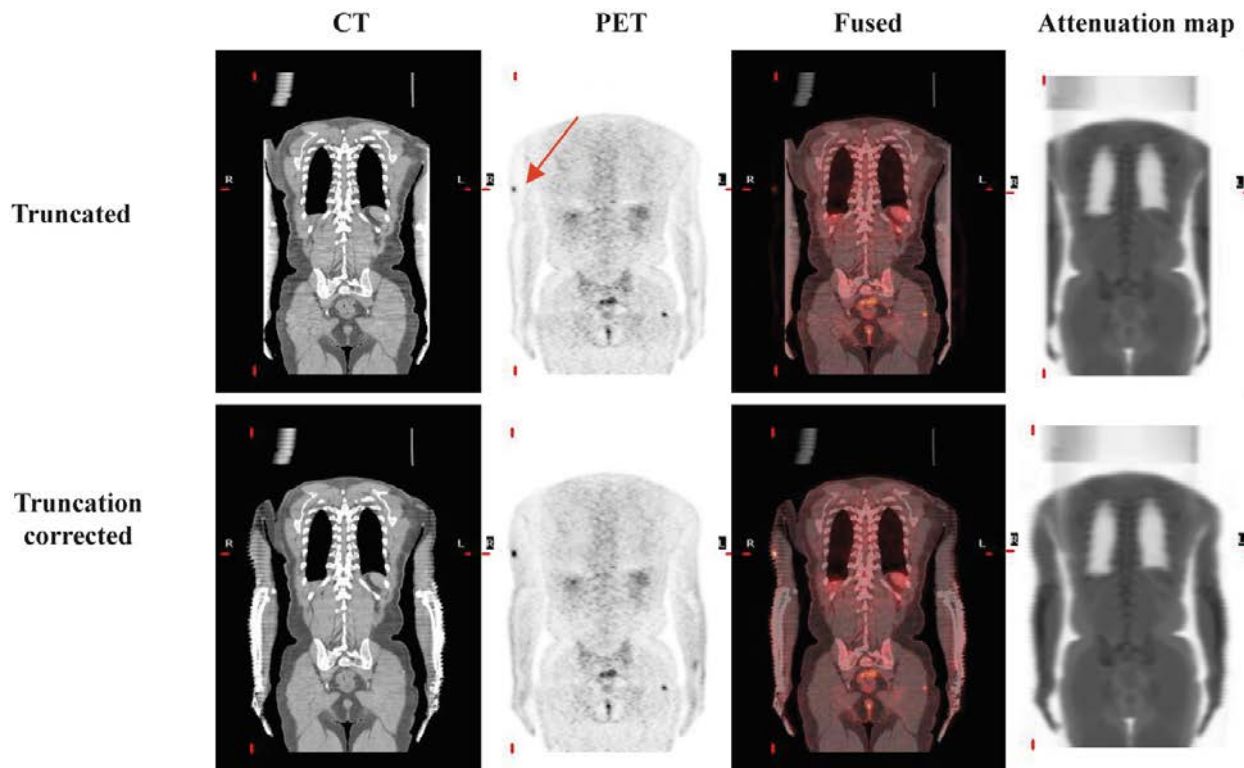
Upper panel: whole body FDG-PET/CT study of a patient positioned with arms down, demonstrating truncation artefacts along the arms. Lower panel: the same images following truncation correction with extended field of view reconstruction. From left to right: CT, AC-PET, fused AC-PET/CT and CT based attenuation map. AC: attenuation corrected.
